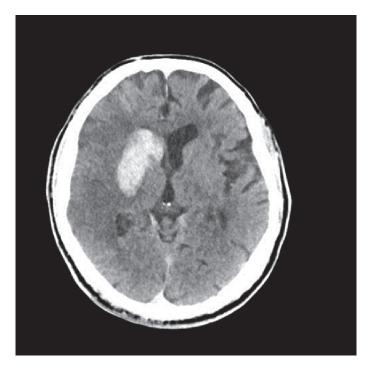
CT of the brain, axial section, view of hemorrhagic stroke. Source: CHC Rijeka database (retrieved June 30, 2021)
